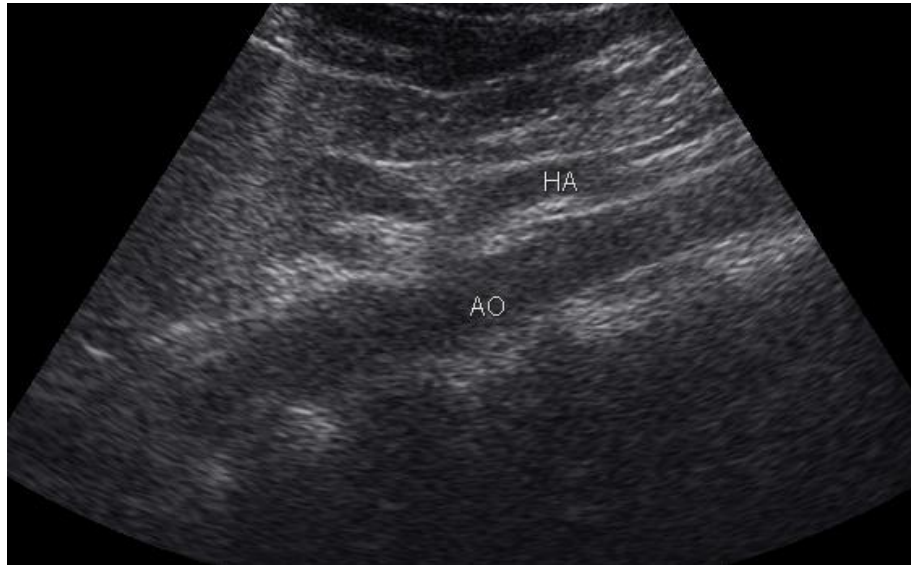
Ultrasonographic vertical scan through, hepatic artery (HA) and aorta (AO).
